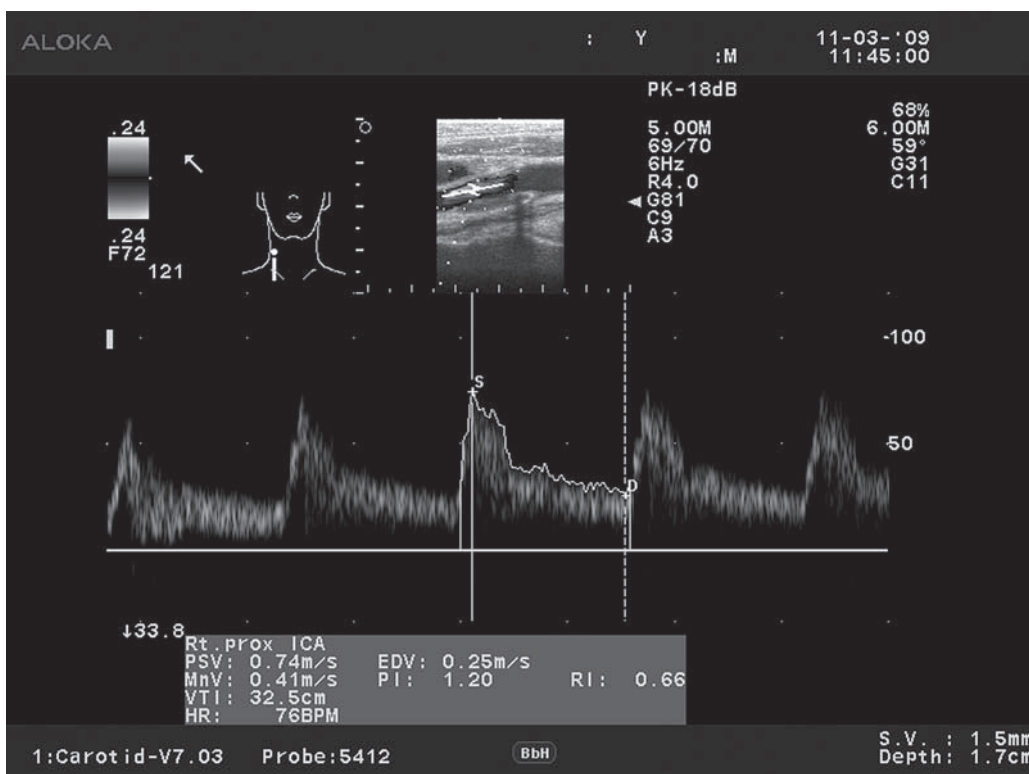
Color duplex carotid ultrasound scan shows satisfactory blood flow and velocity measurements of spontaneously recanalized right ICA after a 5-month follow-up (ProSound Alpha 10, UST-5412 4-13 MHz 36mm High Frequency Linear Probe with Harmonic Echo Imaging)
